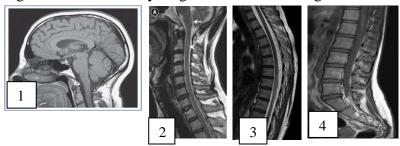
Magnetic Resonance images showing the brain (1), cervical segment of the spine (2), thoracic segment (3) and lumbosacral segment (4).
